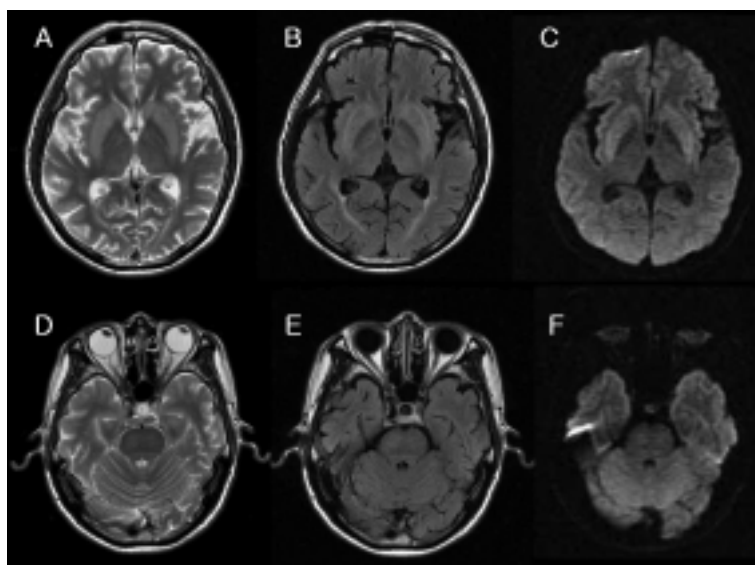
Brain magnetic resonance imaging (MRI) scans. T2-weighted images show abnormal high signal intensities in the caudate nucleus and putamen (A). Fluid-attenuated inversion recovery and diffusion-weighted images show high signal intensities in the corresponding areas (B and C). There are no abnormal signal intensities in the pons (D–F).
